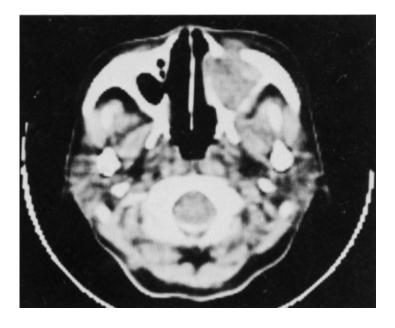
The initial CT of Case 9 showing bone defects of the posterior-lateral wall of the left maxillary sinus and tumor infiltration into the infratemporal fossa.
